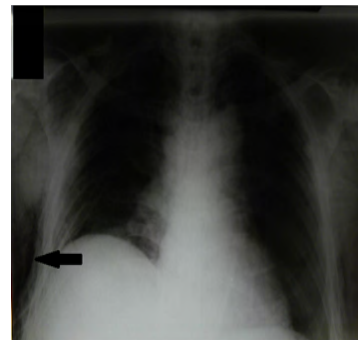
Chest X-ray evidencing the subcutaneous emphysema area on the lateral region at right; possible fractures were ruled out.
